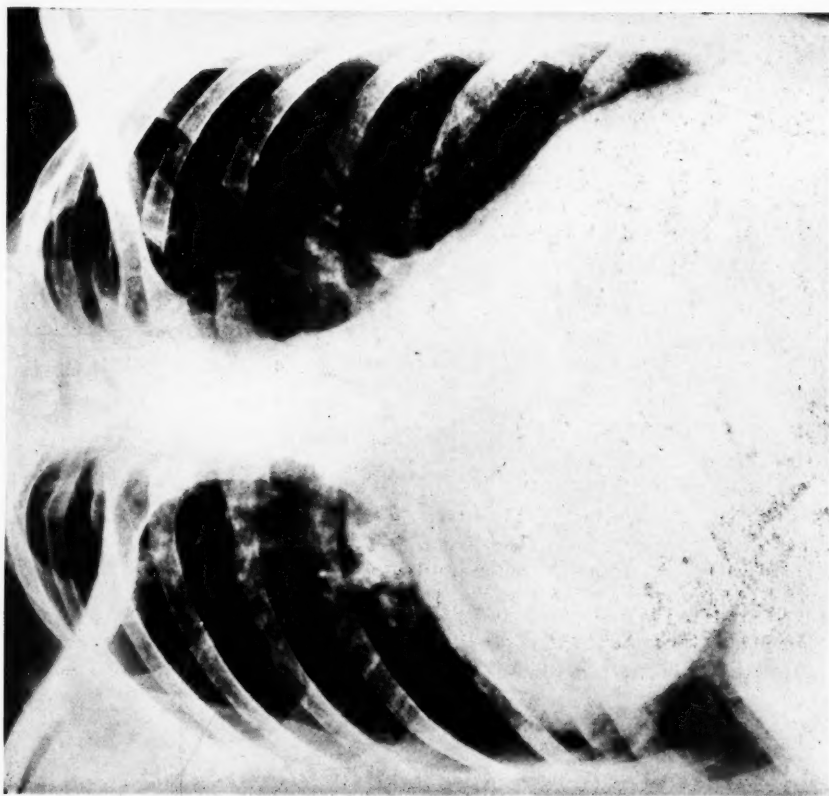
Case 1. Postero-anterior radiograph showing a massive left auricle, an enlarged left ventricle, and depression of the right lesser fissure
